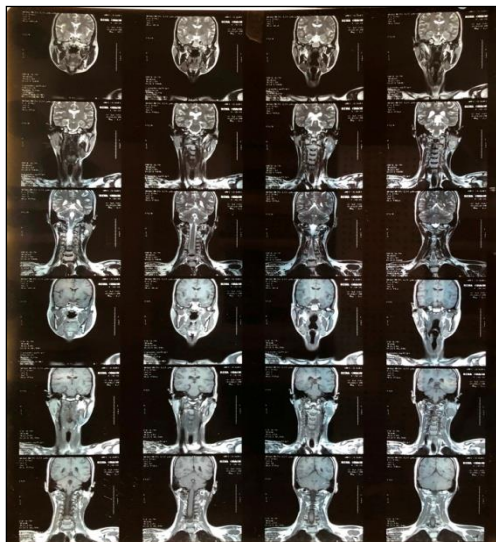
CT scan revealing left parotid gland tumor.
